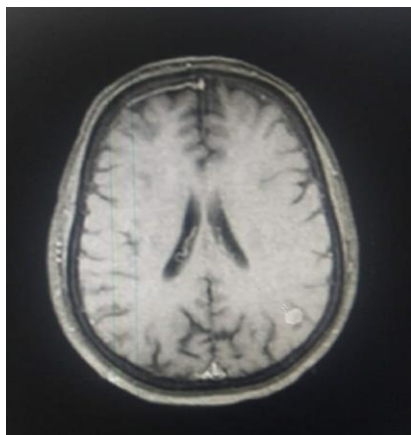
MRI showing pachymeningeal enhancement.
